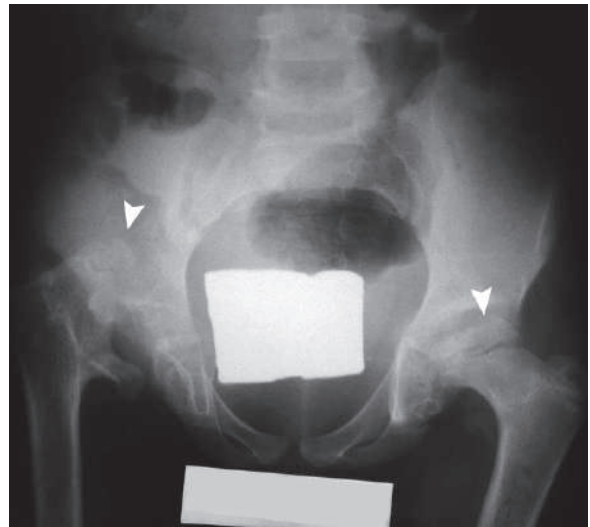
Anteroposterior plain hip radiograph of a child with multiple epiphyseal dysplasia shows bilateral femoral epiphyses fragmentation and flattening (*arrowheads*), with right hip dislocation
